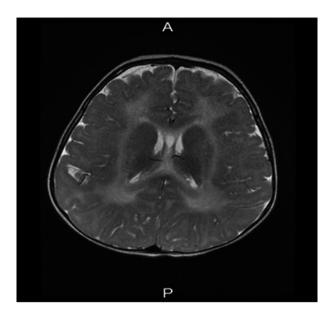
MRI of the brain showing the diffuse VWM changes.
